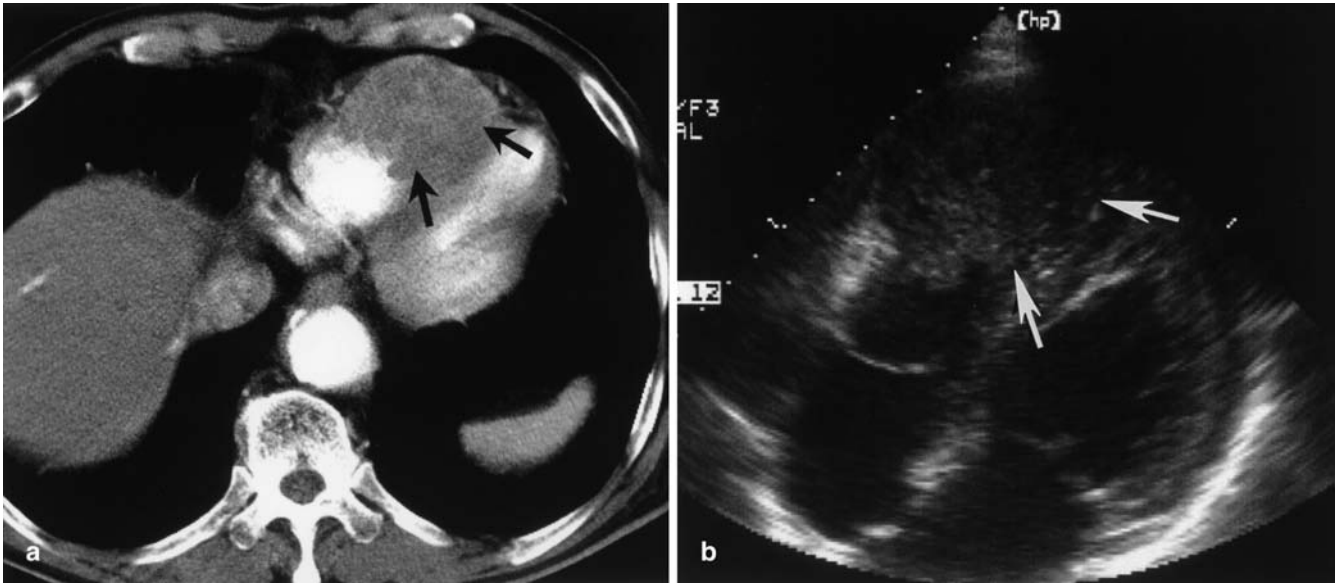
Heart metastasis. a Enhanced CT scan shows an irregular hypoattenuating mass (*black arrows*) in the right ventricle. b Echocardiography shows an ill-defined hypoechoic mass (*white arrows*) in the right ventricle
